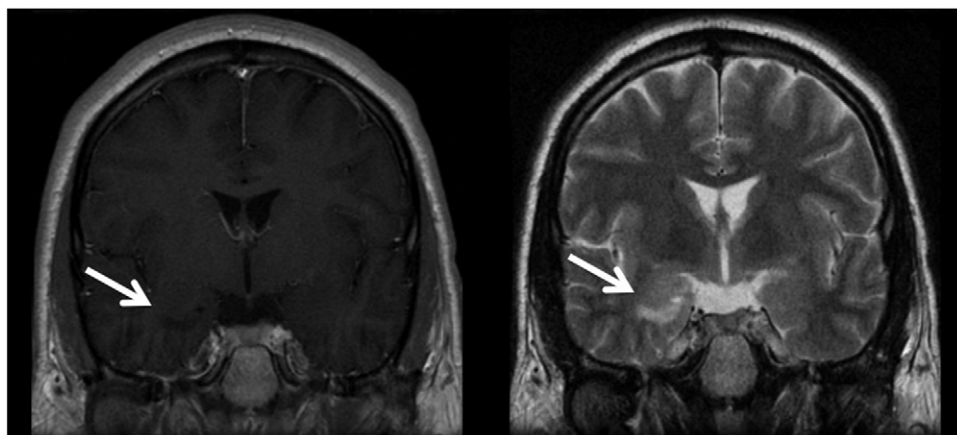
Representative preoperative MR images showing a patient with intractable epilepsy and a right temporal lobe ganglioglioma. The lesion is hypointense on T1 (arrowed, left) and hyperintense on T2 (arrowed, right).
